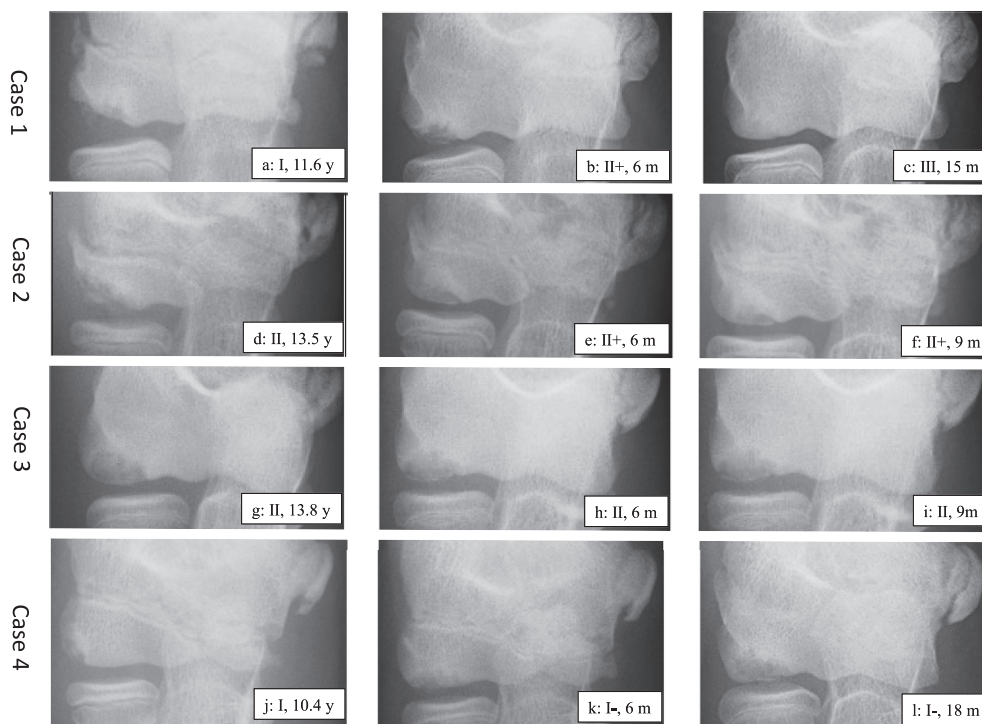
Radiographic OCD stages. Anteroposterior radiographs with the elbow in 45° of flexion in Case 1, an 11.6-year-old baseball player (a, b, c); Case 2, a 13.5-year-old baseball player (d, e, f); Case 3, a 13.8-year-old baseball player (g, h, i); and Case 4: a 10.4-year-old baseball player (j, k, l). APR45 at the initial presentation (a, d, g, j), and 6 months (b, e, h, k), 15 months (c), 9 months (f, i), and 18 months (l) after the initial presentation. Stage I, localized flattening or radiolucency (a, j); Stage I-, stage I with obvious enlargement of the lesion width (k, l); Stage II, delayed ossification or nondisplaced fragment (d, g, h, i); Stage II+, stage II with partial bony union and an obvious decrease in lesion width (b, e, f); and Stage III, normal or bony union of the delayed ossified fragment with the surrounding bone (c). The periods required for a return to sports were 12.4 months in Case 1, 7.8 months in Case 2, 0.9 months in Case 3, and 19.0 months in Case 4. The mean stage was calculated as follows: stage I-, zero points; stage I and II-, one point; stage II, 2 points; stage II+, 3 points; and stage III, 4 points. OCD, osteochondritis dissecans.
